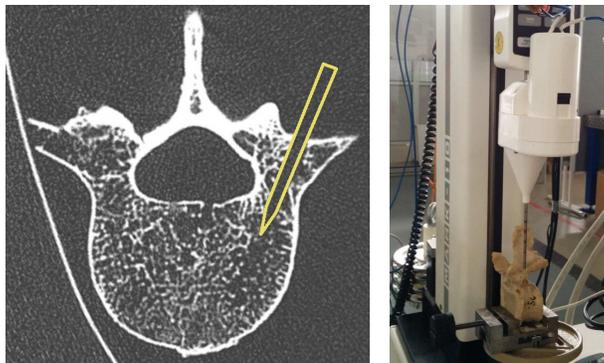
Left*: 10 s Dyna-CT scan with highlighted insertion path for a conserved lumbar vertebrae. *Right*: Experimental setup where forces are measured during automatic drill insertion with constant velocity of 2 mm per second.
